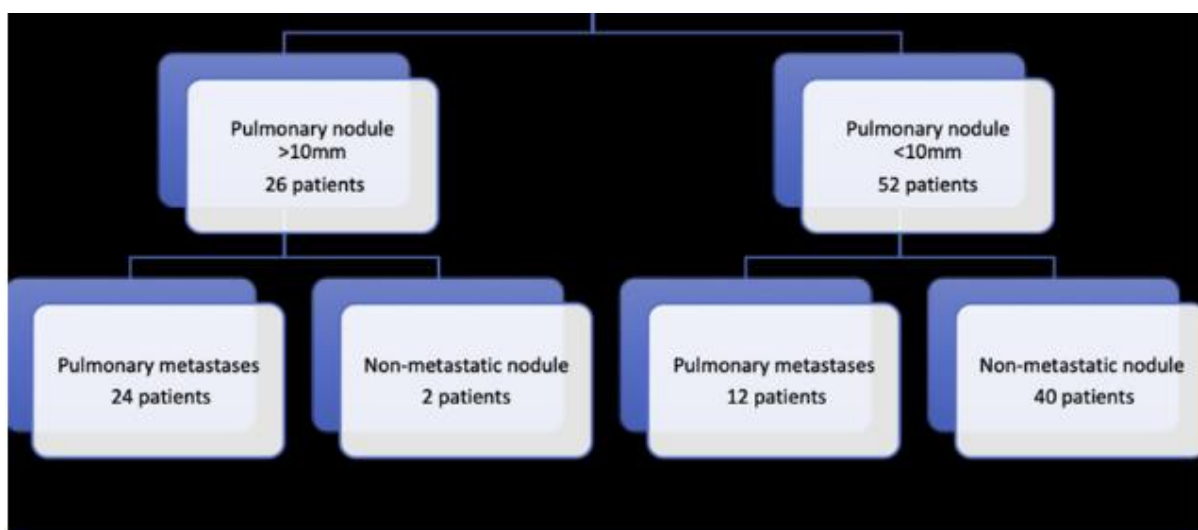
The diagnostic significance of pulmonary nodules on CT thorax in chondrosarcoma of bone, McLoughlin et al [79], with permission from Elsevier publishing
